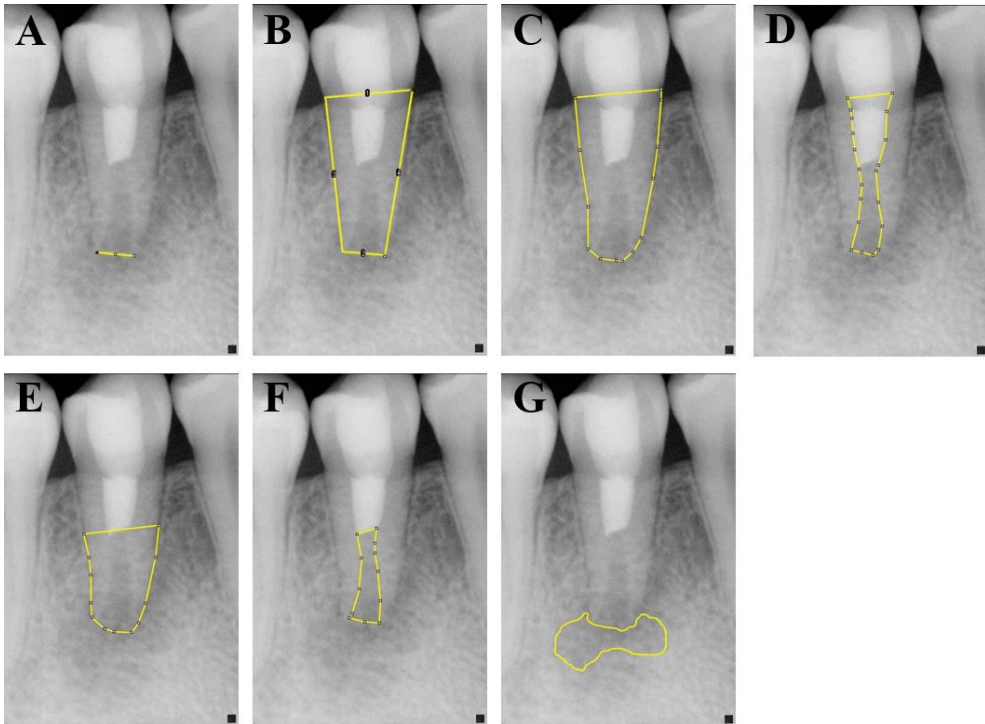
Digital measurements of four radiographic changes: (A) apical diameter, (B) root length, (C, D) RRA according to Flake *et al.* [16], (E, F) modified RRA, (G) periapical rarefaction area. *RRA*, radiographic root area.
